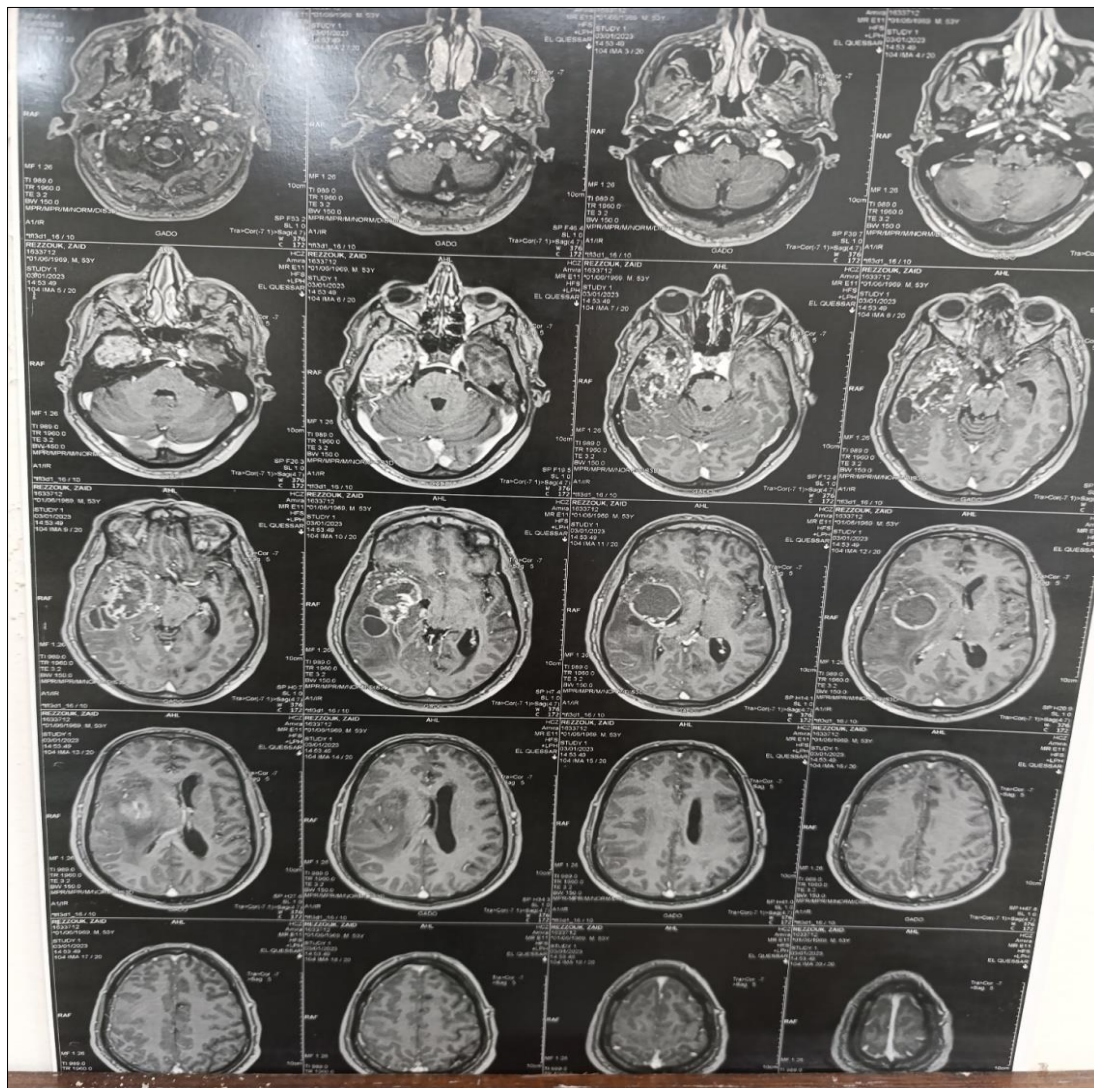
Brain MRI in axial sections. Showing a heterogeneous right temporo-parietal mass with a dual cystic and solid component and intense enhancement
